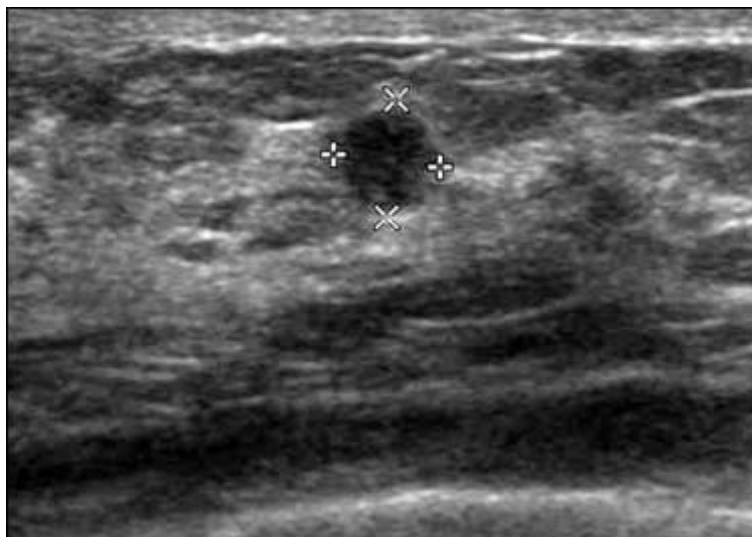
A 52-year-old female presented for check-up. Sonography revealed a circumscribed hypoechoic mass at lower inner quadrant of right breast. Excision confirmed intraductal papilloma.
